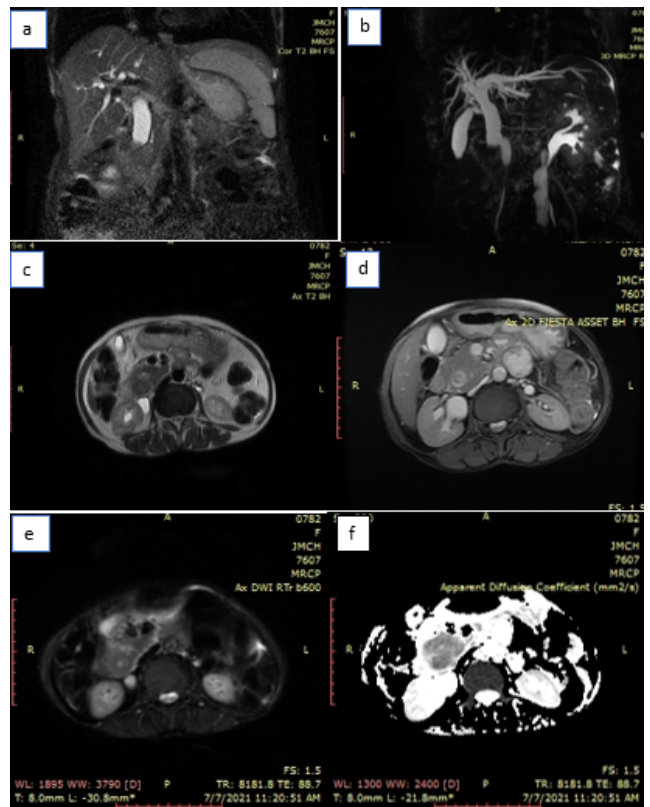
Coronal T2W; a: and 3D MRCP; b: Images showing dilated CBD with distal abrupt narrowing, another axial T2W; c: and axial 2D FIESTA; d: Images showing a poorly subtle iso to hyperintense intraductal lesion in the distal 3rd of the CBD which is showing restricted diffusion on DWI & ADC; e & f: and mild post contrast enhancement (image not given).—Intraductal cholangiocarcinoma of distal CBD was confirmed in ERCP guided biopsy.
